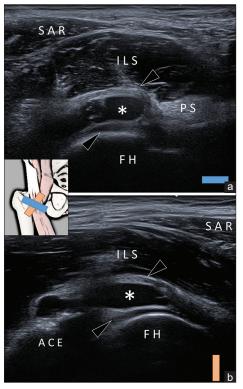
(a) short-axis and (b) long-axis ultrasound imaging of the anterior hip. Asterisk: the lesion, Arrowheads: labrum, SAR: Sartorius muscle, ILS: Iliacus muscle, PS: Psoas tendon, FH: Femoral head, ACE: Acetabulum
